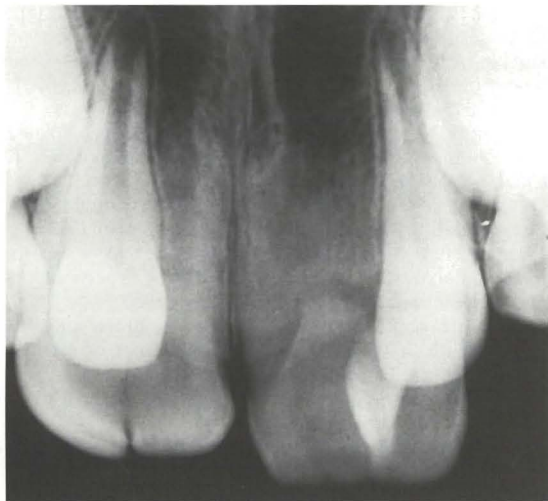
Case 2. Occlusal radiograph showing the upper central incisors with a single pulp chamber and root canal. The lateral incisors had a normal morphology.
